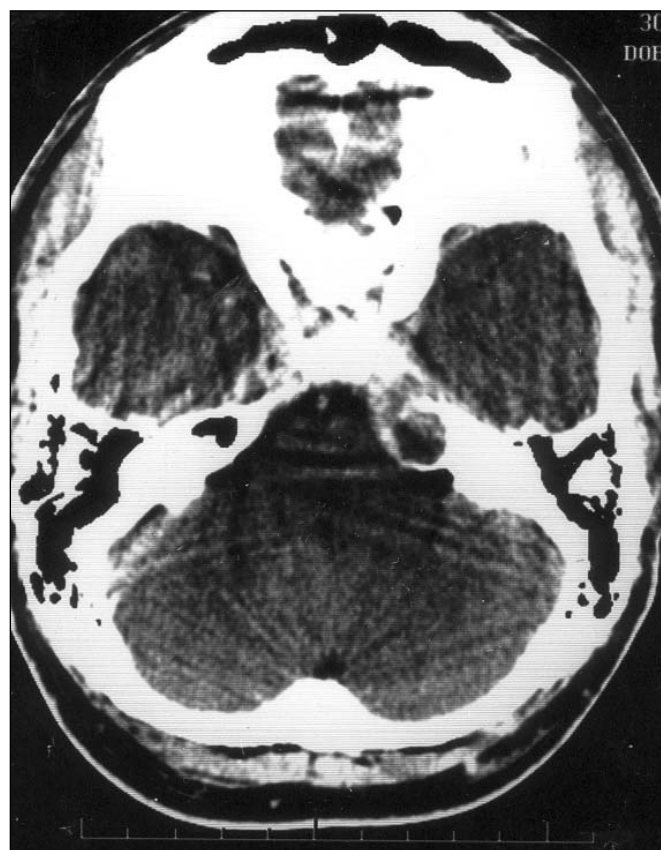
CT scan demonstrating erosion and expansion of the left petrous apex by a low-density lesion.
